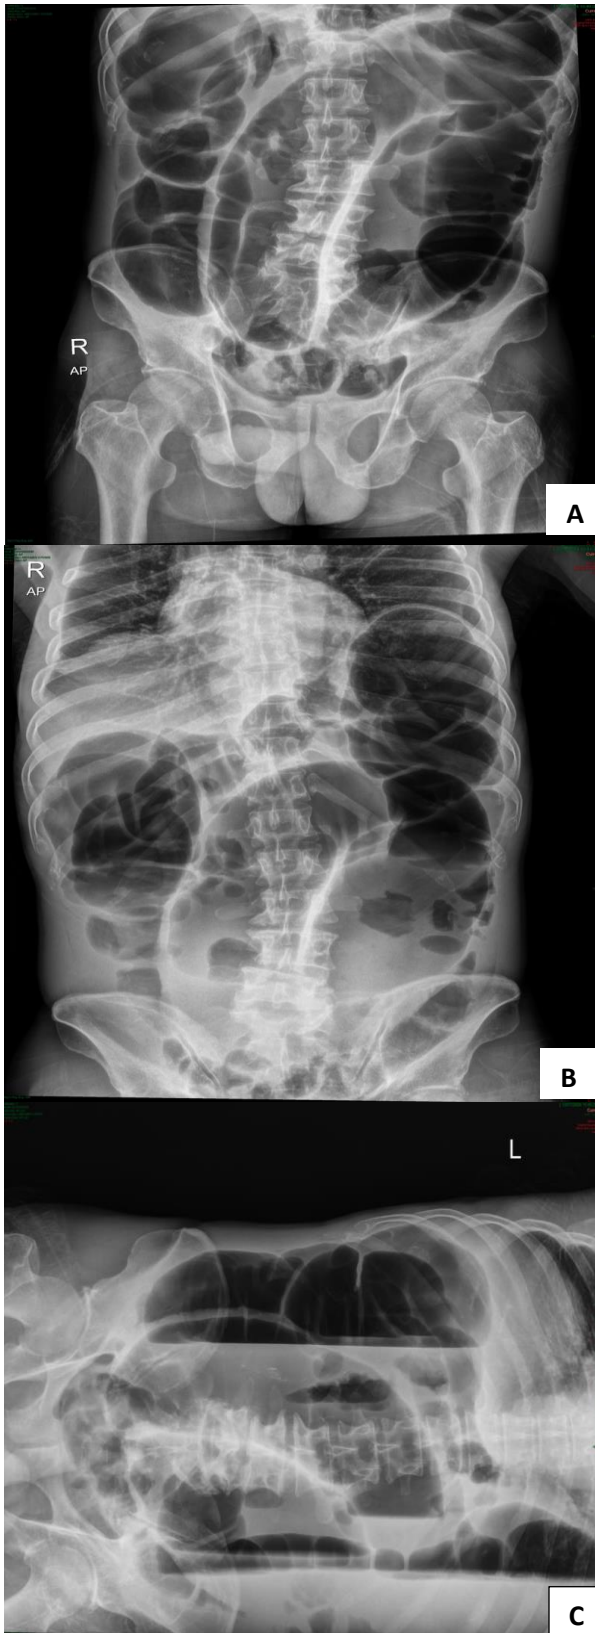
(A-C) Abdominal plain X-ray (3 position): absence of rectal gas with coffee bean shaped dilatation of the sigmoid colon and radio-opaque lines which converge toward the site of obstruction as well as moderate dilatation of the proximal colons. Air fluid level step ladder pattern.
